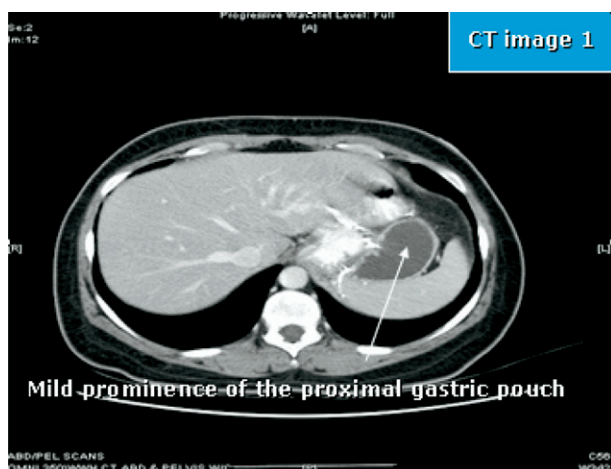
Computed tomography (CT) scan showing mild prominence of proximal gastric pouch.
